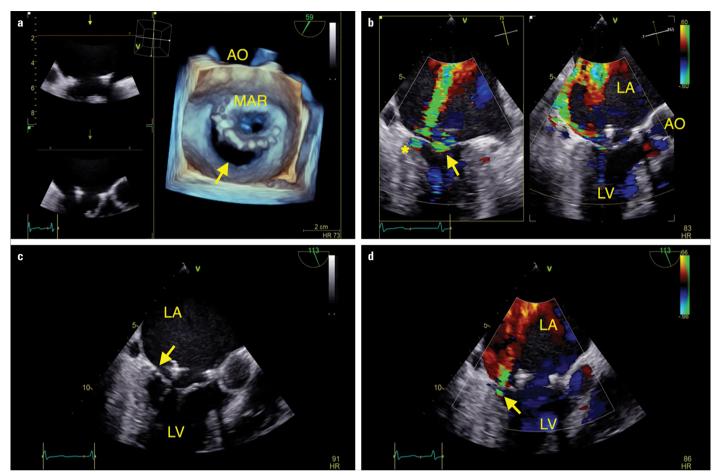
(a) Three-dimensional transesophageal echocardiography imaging of the mitral ring dehiscence. (b) The first jet originated from the perimitral ring (arrow) and the second jet (asterisk) came from the basal portion of the posterior mitral leaflet. (c) Image of the defect in the basal portion of the posterior mitral leaflet in the mid-esophageal transesophageal echocardiography view. (d) Increase of the mitral regurgitation jet from the defect in the basal portion of the posterior mitral leaflet, which possibly occurred after the separation of the mitral ring suture
